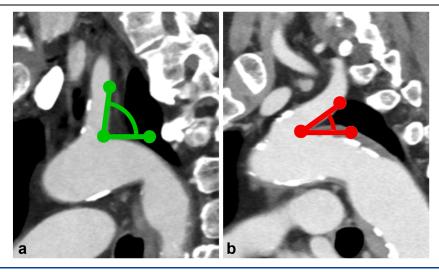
The left subclavian artery incident angle was measured using the sagittal plane of chest computed tomography (CT), defined as the angle between the line of the subclavian artery origin and the horizontal plane: (a) an angle of 85° (shown in green), (b) an angle of 27° (shown in red). Since angle in (b) was <50°, it was not eligible for inclusion in the latter period of this study.
